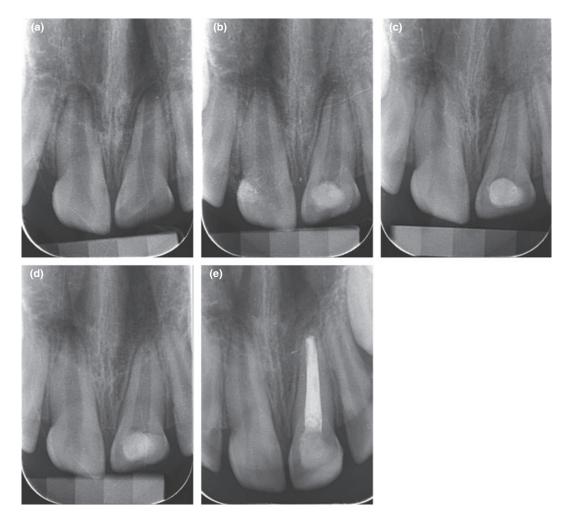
(a) Preoperative radiograph of tooth 21 treated with calcium hydroxide plus points. (b) Three-month follow up. (c) Six-month follow up. (d) Nine-month follow up and apical barrier formation. (e) Final root canal treatment.
